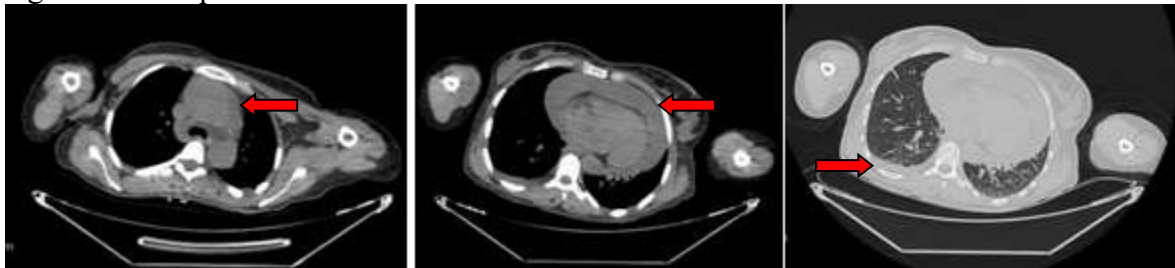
Aneurysm in the ascending aorta, fluid in the right hemithorax and pericardial mai in thorax CT
